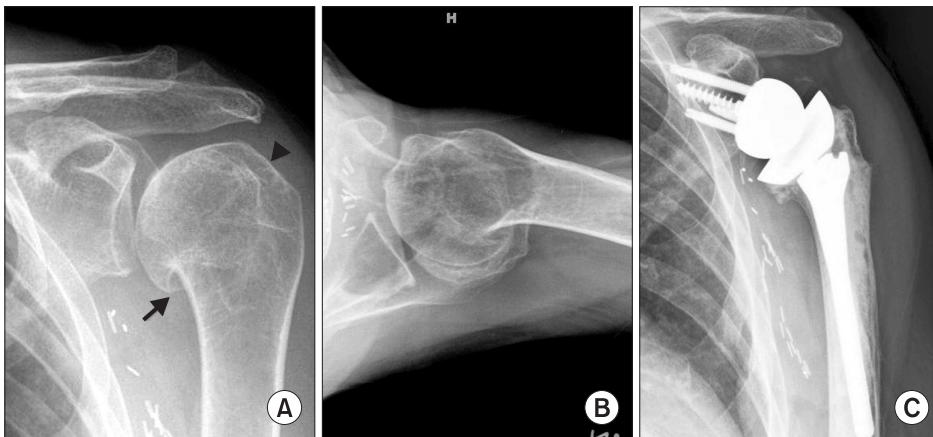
A 78-year-old female patient with proximal malunited fracture. (A) Preoperative conventional anteroposterior radiograph of the shoulder shows distorted greater tuberosity (arrow head) and inferior part of humeral head (arrow). (B) Preoperative axillary radiograph of the shoulder also shows distorted alignment between the head and shaft. (C) Conventional anteroposterior radiograph of the shoulder at 2 years' follow-up shows a well-fixed prosthesis.
